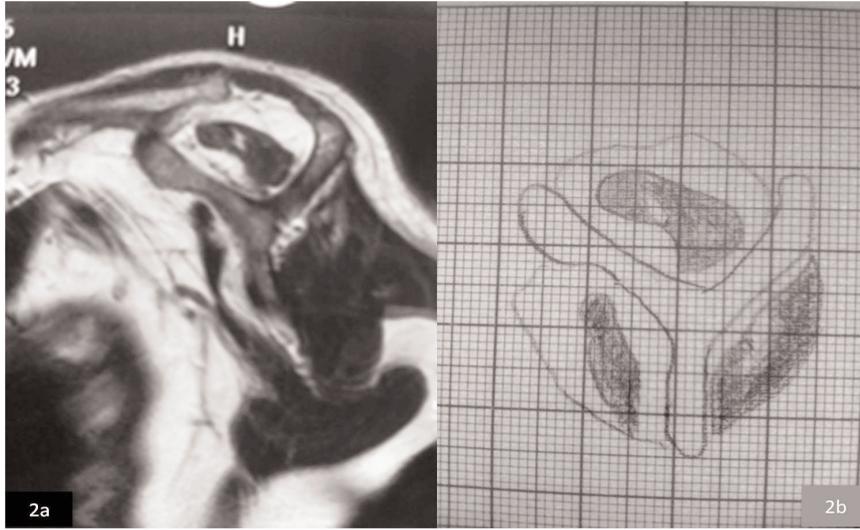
Calculation method of the rate of the fatty degeneration to the whole muscle mass on scapula Y planes on MRI (a) by using standard millimetric papers (b).
